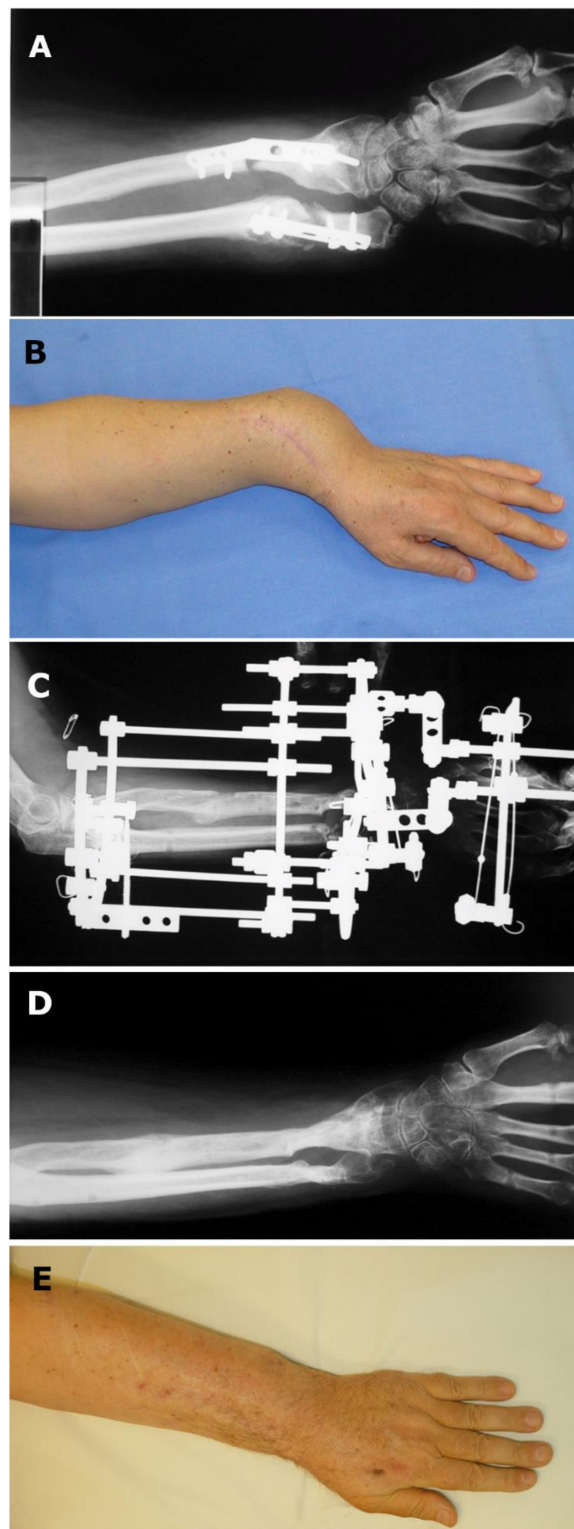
Nonunion. Male, 57 years old. Post-traumatic nonunion of the forearm, treated with plates (A,B). Ilizarov treatment for 6.5 months. Lengthening of the radius and compression at the level of the nonunion. Started LIPUS treatment (and continued for 60 days) (C). X-ray 3 months after fixator removal (D). Clinical healing with the restoration of forearm length, normal distal radius and ulna ratios, and wrist function (E).
